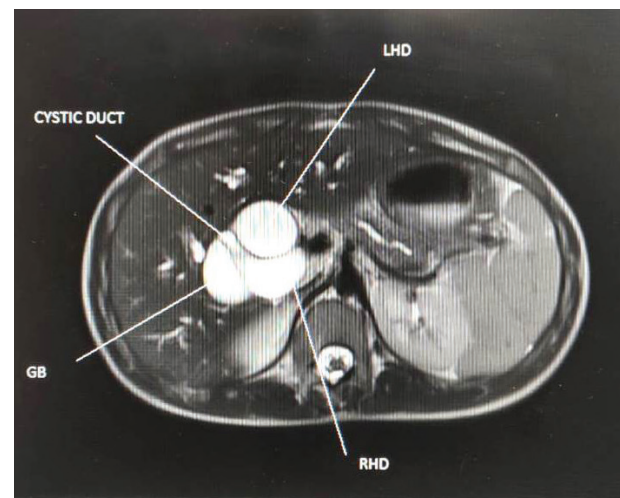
MRI photograph showing the cystic duct draining into the right hepatic duct in its medial wall.
